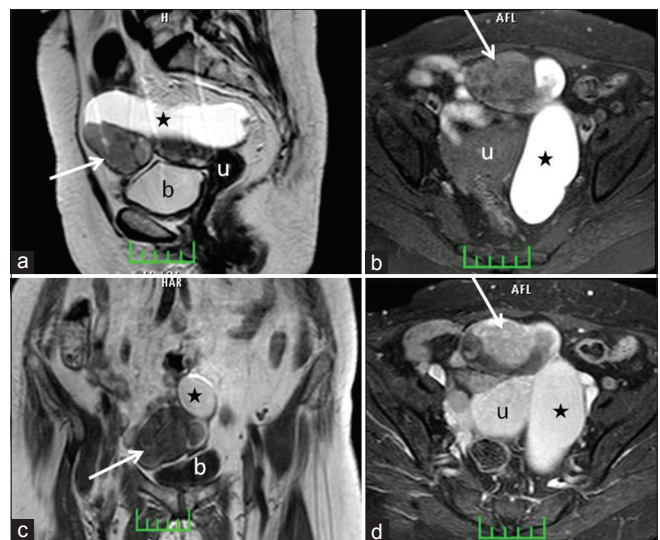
Pelvic MR images of the patient: (a) sagittal T2 weighted (T2W) magnetic resonance imaging (MRI); (b) coronal T1 weighted (T1W) MRI; (c) axial fat-suppressed T1W MRI; (d) axial fat-suppressed contrast-enhanced T1W MRI. MR imaging reveals that the fallopian tube (asterix) is filled with blood, as the content is hyperintense on both T1 and T2W images and shows no signal loss on fat-suppressed series. The soft tissue mass on the distal end of the tube (arrow) is of intermediate intensity on T1 and T2W images and strongly enhances after contrast material administration. u: Uterus; b: Bladder
